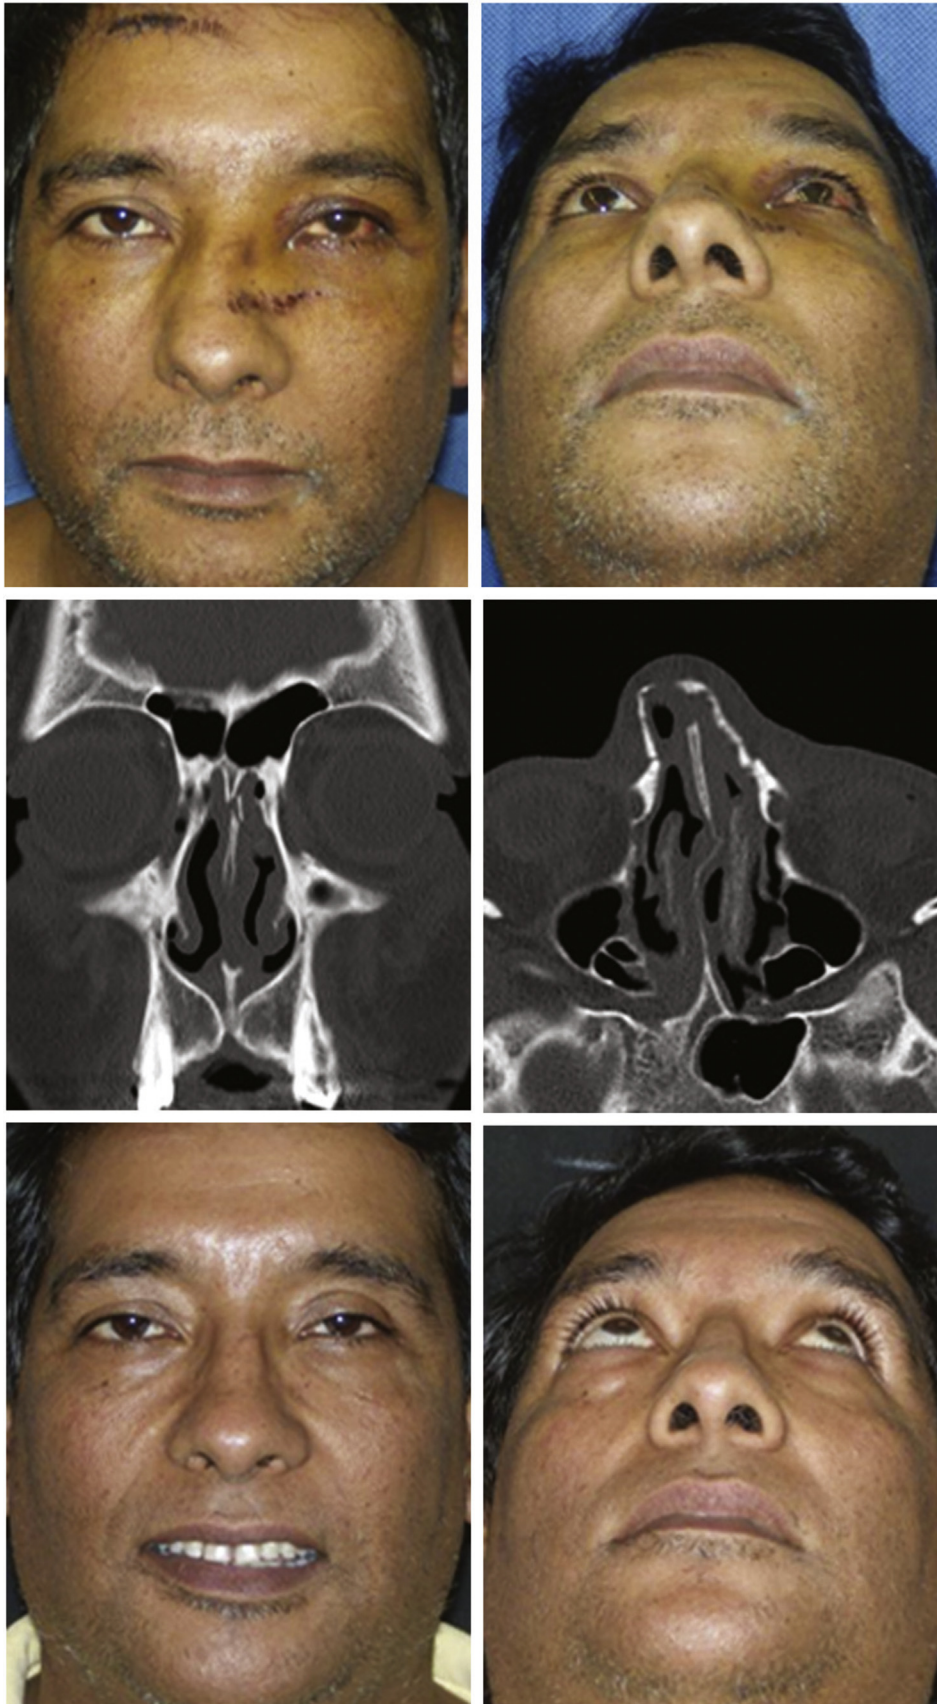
Patient with isolated nasoseptal fracture. Preoperatively (above), Maxillofacial CT scan showing the fracture (center); Ten months postoperatively (below).
